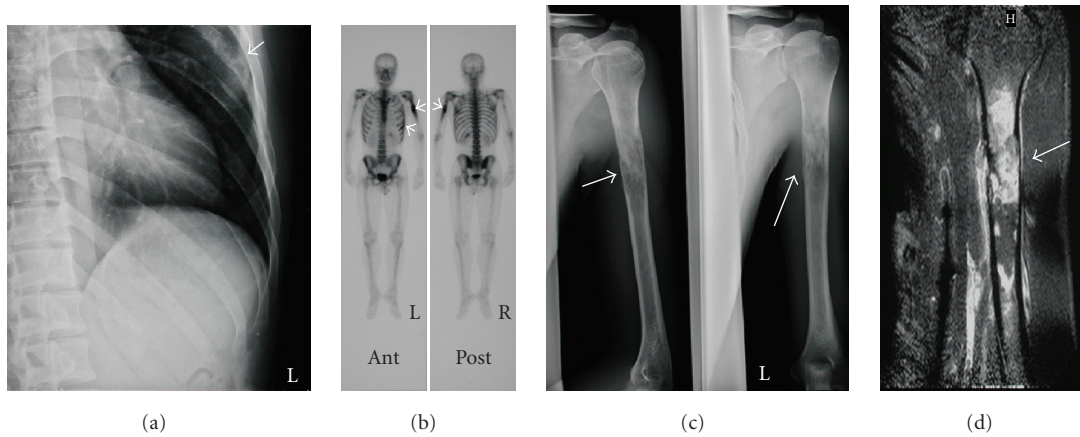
(a) Plain radiogram showing bone destruction of the rib (arrow). (b) Bone scintigram showing increased spots in the bilateral humerus and the left rib (arrow). (c) Plain radiogram of the left humerus showing an osteolytic lesion (arrow). (d) T1 weighted magnetic resonance imaging showing gadolinium enhancement (arrow).
